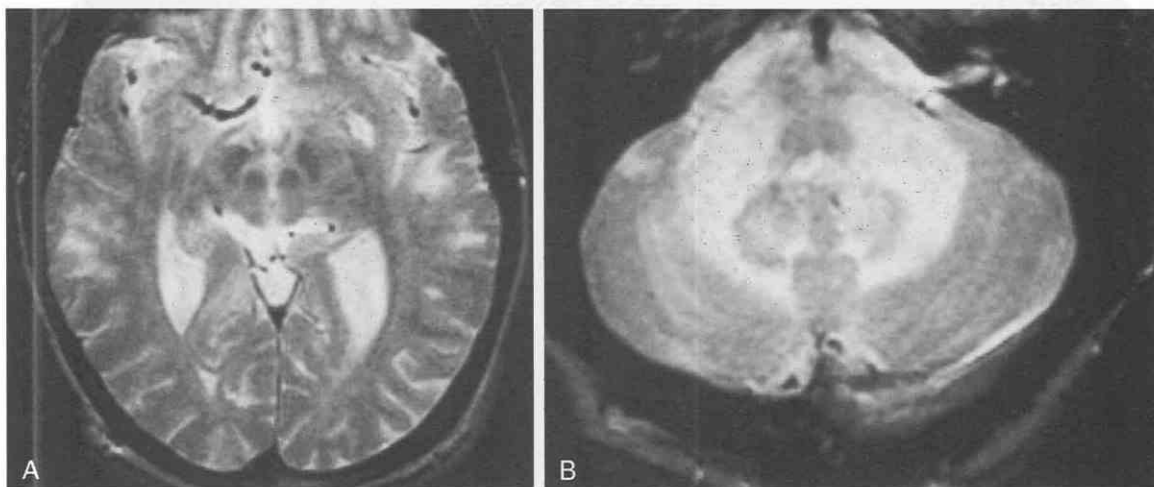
Progressive multifocal leukoencephalopathy (PML) in a 44-year-old man with chronic lymphocytic leukemia. Cranial T2-weighted axial MR images. A, At the level of the midbrain, there are bilateral temporal white matter lesions, with complete sparing of the overlying cortex. B, Symmetrical, hyperintense cerebellar white matter lesions are seen in the brachium pontis and corpus medullaris. The diagnosis of PML was confirmed by biopsy.
